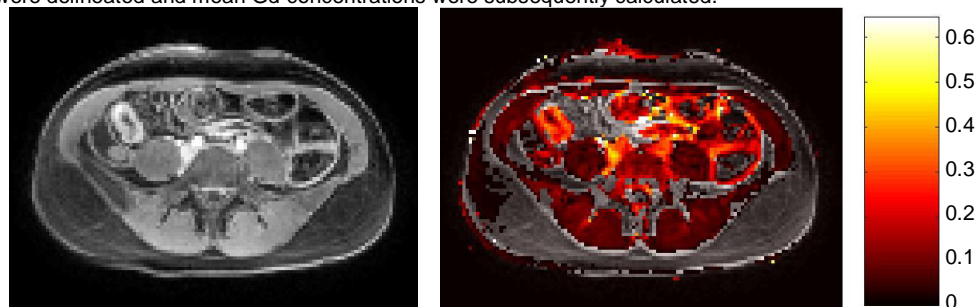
(left image): post-contrast T1-weighted transversal image.
